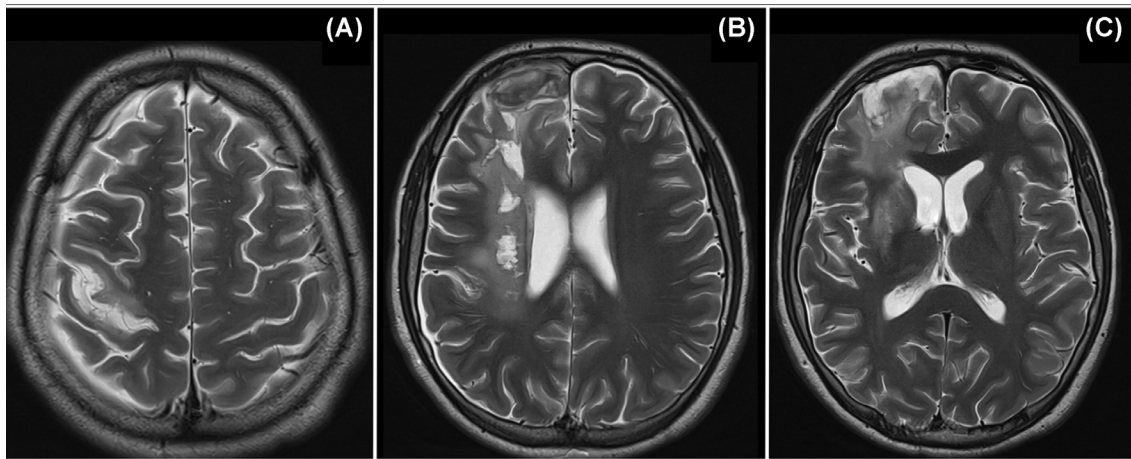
About 2 months post progress brain MRI T2 sequence. (A) Cortical enhancement at posterior right frontal lobe/parietal lobe post cerebral ischemia with gliotic changes. (B and C) Interval progression of right frontal lobe white matter encephalomalacia and surrounding gliotic changes.
